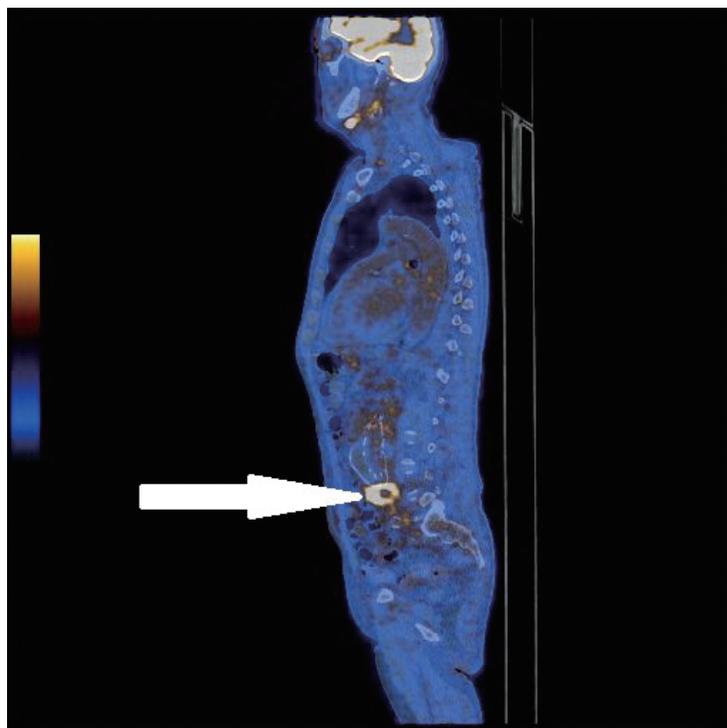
PET-CT, sagittal plane, patient after implantation of the aortic graft. Arrow marks the focus of intensively increased glucose uptake in the retroperitoneal space, on the border of the abdominal aorta and the left iliac artery – limited inflammatory infiltration of the graft.
